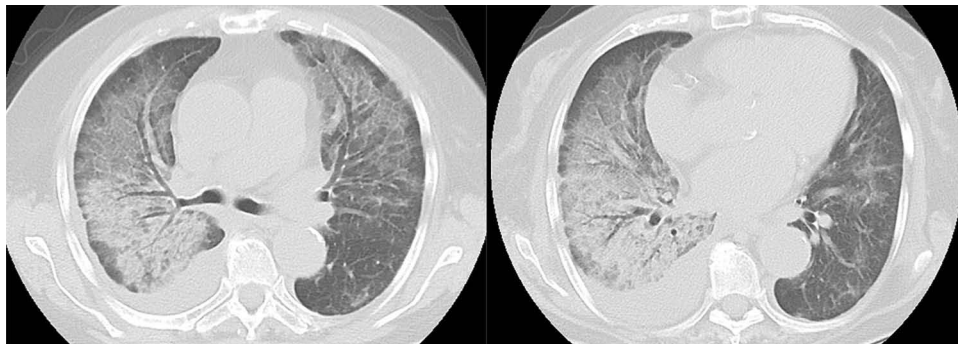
Computed tomography imaging of osimertinib-induced interstitial lung disease in case 1 showing an organizing pneumonia pattern.
